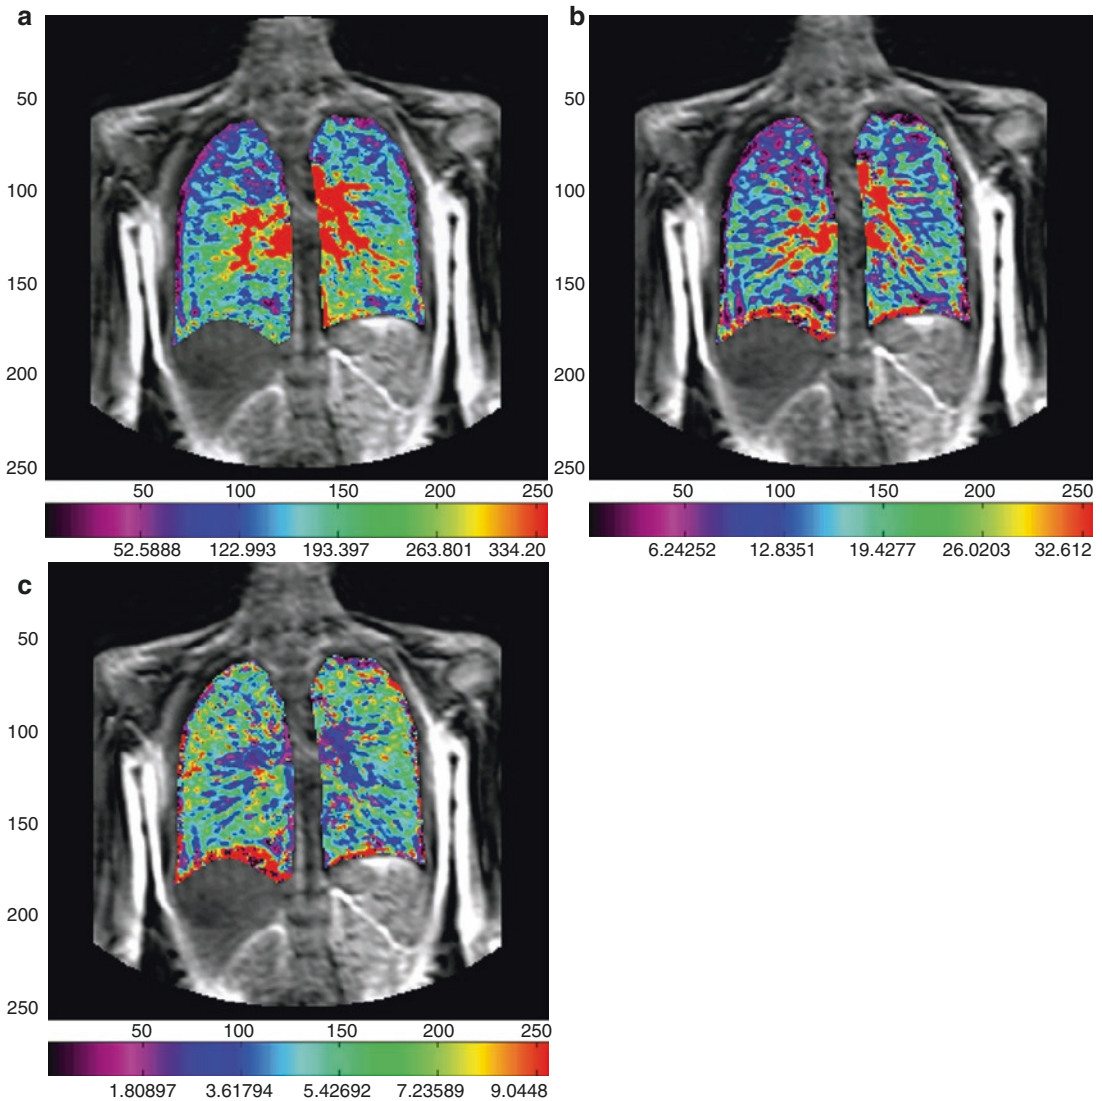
Lung perfusion quantification image. Using perfusion MRI technique, PBF map (a), a PBV map (b), and an MTT map (c) are generated
